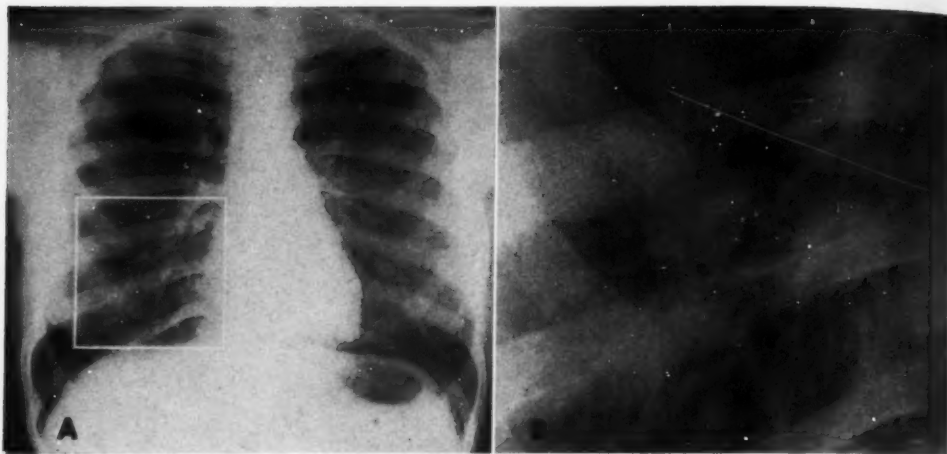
A. Roentgenogram of a patient with acute respiratory infection.
